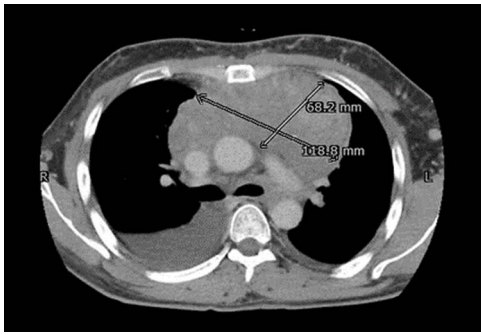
CT chest with contrast showing large heterogeneous mass.
